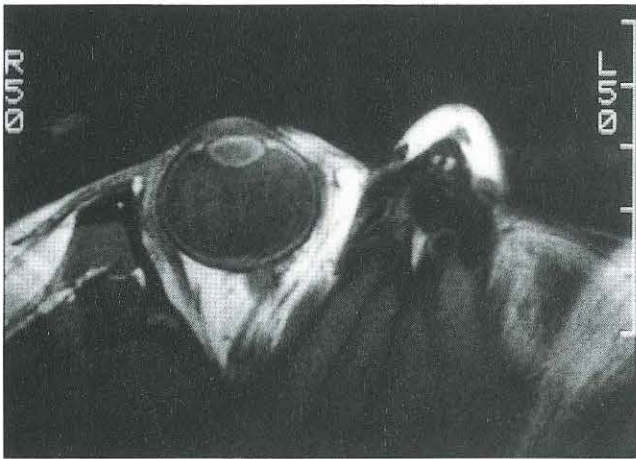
MR image of choroidal detachment. The MRI parameters are the same as that in figure 1.
